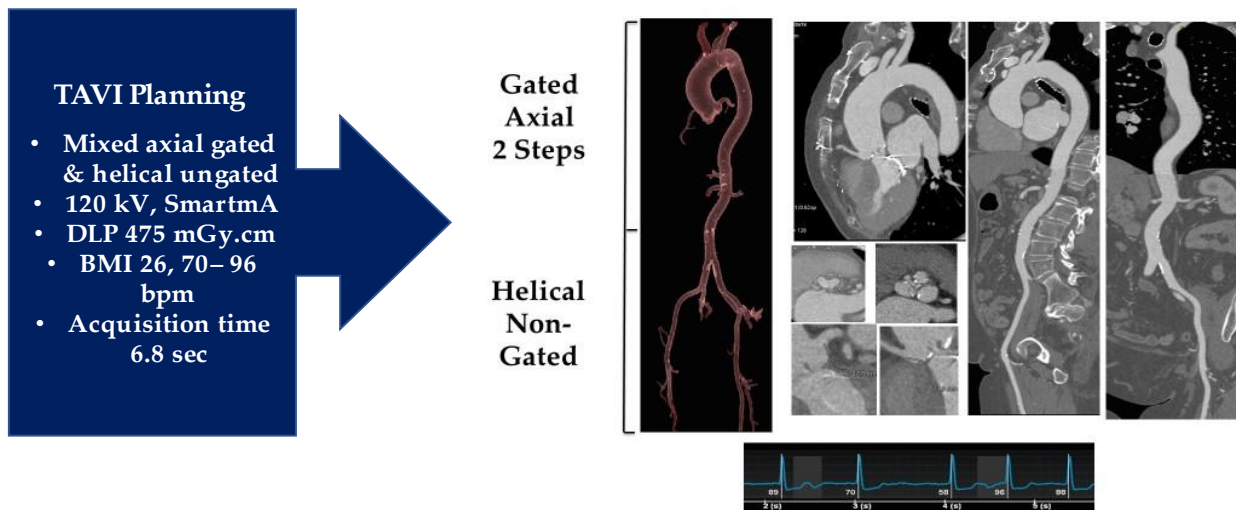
Depict the 3D CT Scan protocol for patients receiving TAVI. It is designed to ensure all steps of the transcatheter procedure. The figure report an example in which the exam was done in 6.8 sec with only 640 mGy.cm. A precise planning to support the intervention was conferred. Abbreviations; DLP, Dose Length Product; mGy, microgray
